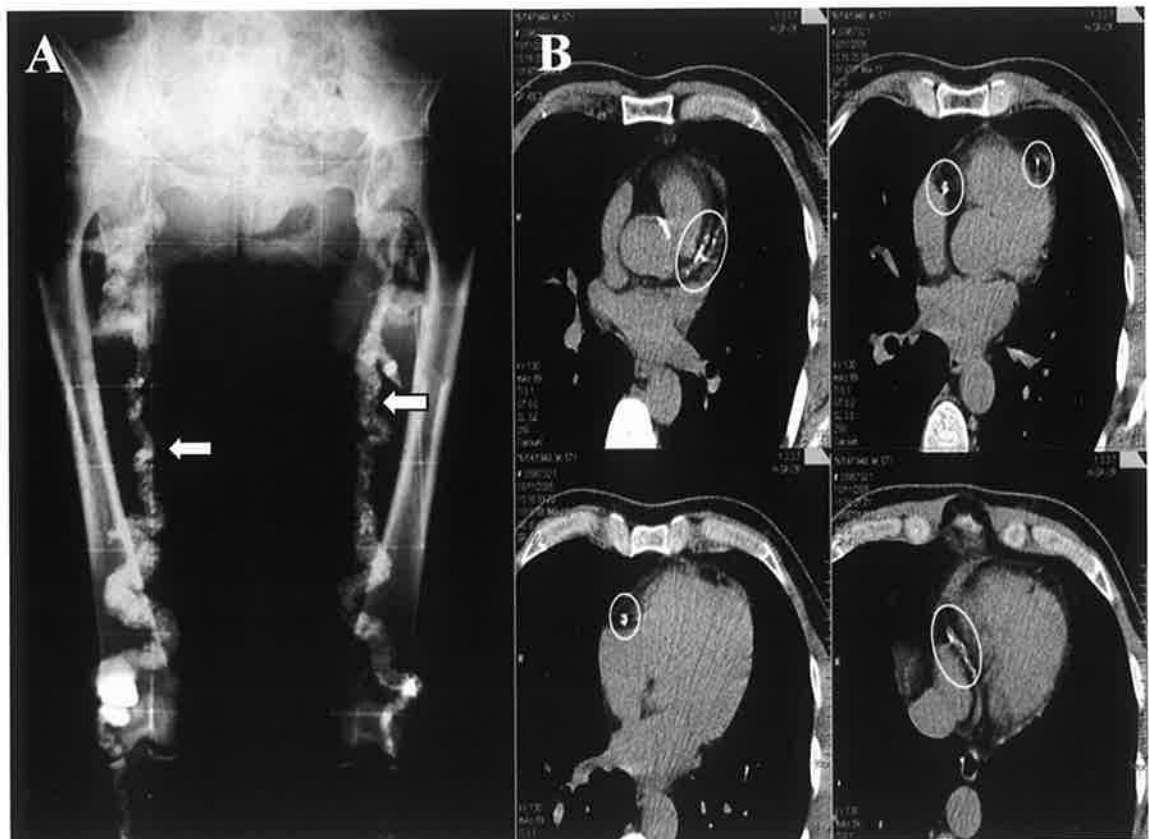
A: Extensive VC of the femoral arteries on plain film xray, indicated by white arrows. Adapted and reproduced with permission from Couri *et al* [13]. B: Computed tomography of the coronary arteries, with areas of calcification circled. Adapted and reproduced with permission from Piers *et al.* [14]. VC, vascular calcification.
